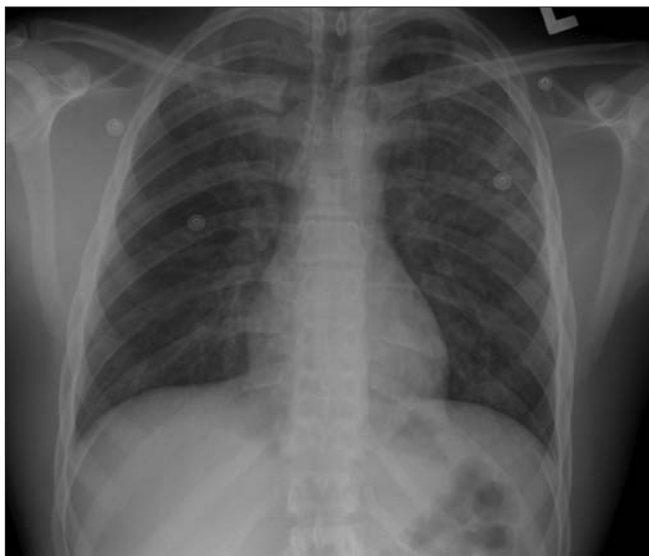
Repeat chest radiographs taken 8 hours after injury showing mild, interval improvement in the upper lobe air-space disease and increased involvement of the mid and lower lung zones.
